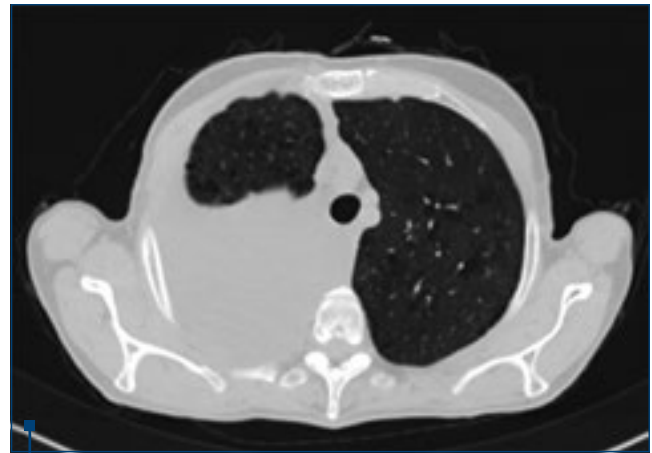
Thoracic CT scan showing massive right pleural effusion
